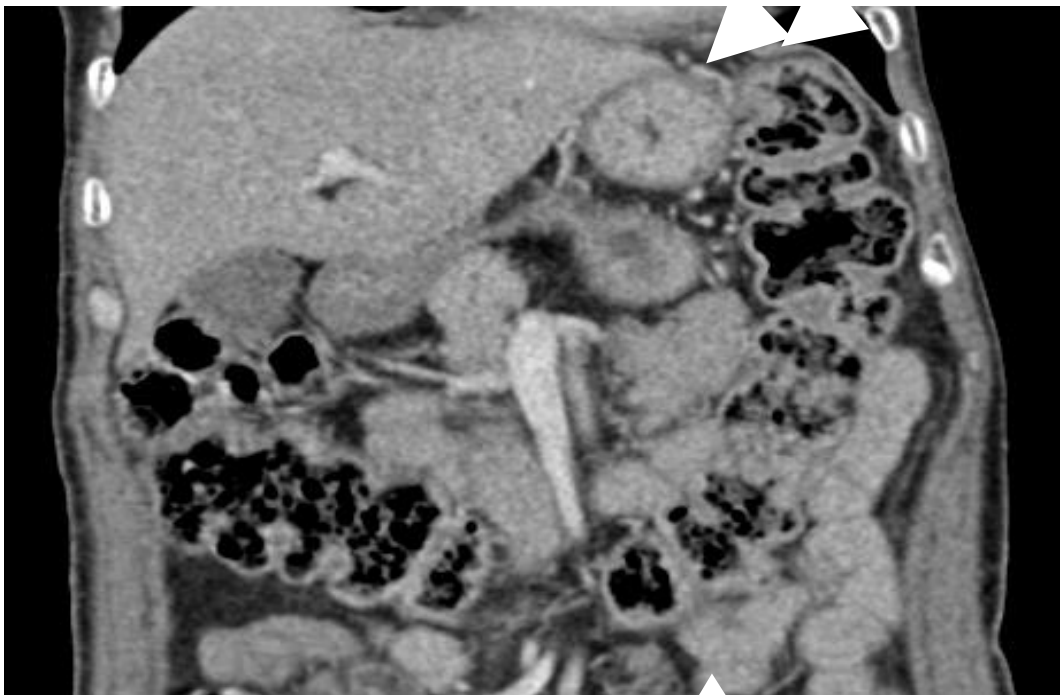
sagittal contrast enhanced computed tomography image shows normal size pancreatic head (Arrow mark) and jejunal loops (arrow head) in pancreatic bed anterior to splenic vein .(Siemens CT Definition AS 128 slice CT (2017).Protocol: 50 mAs, 1mm Slice thickness.
